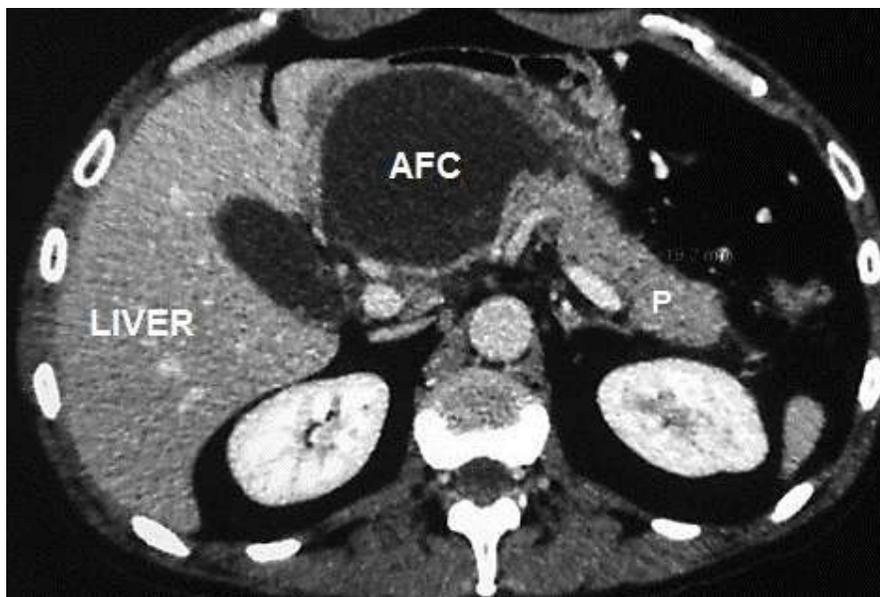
Acute pancreatitis with fluid collection in CT scan
